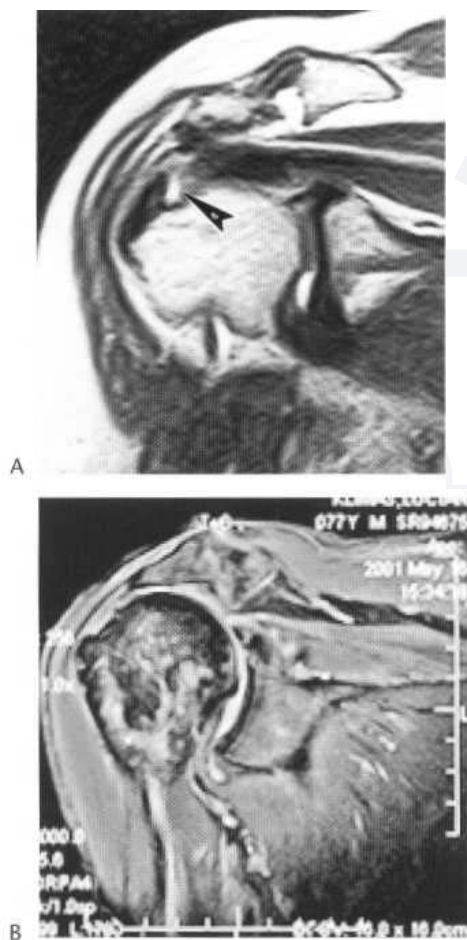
MRI rotator cuff injury. Paracoronal (A) and parasagittal (B) Complete tear of supraspinatus, with retraction of the muscle belly and loss of acromiohumeral joint space.
